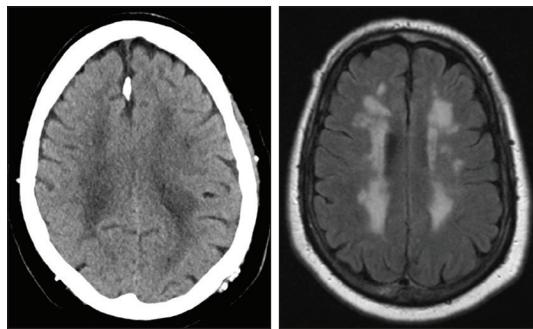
CT (a) and FLAIR MRI demonstrating moderately extensive microvascular changes in a patient with vascular cognitive impairment.
